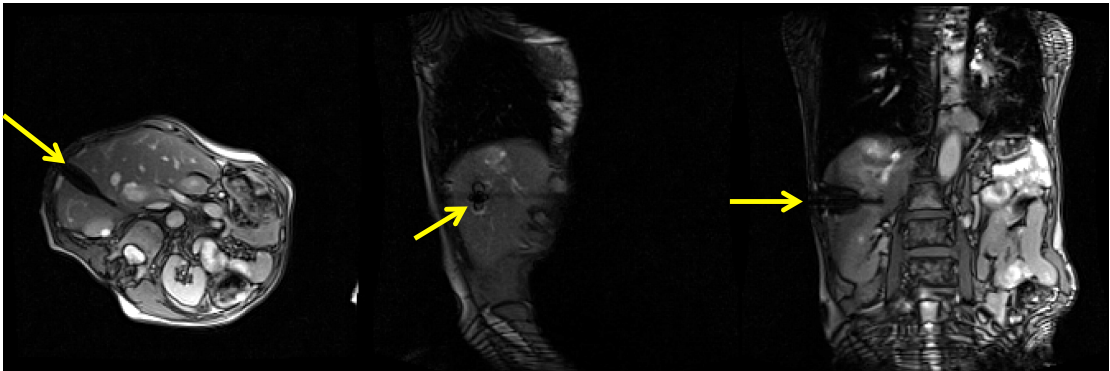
Images of a liver biopsy under MRI-guidance. The image planes at the left and right are orthogonal to each other and aligned to the main axis of the needle. The image plane in the middle is oriented perpendicular to the needle axis. The needle artifact is indicated with yellow arrows.
